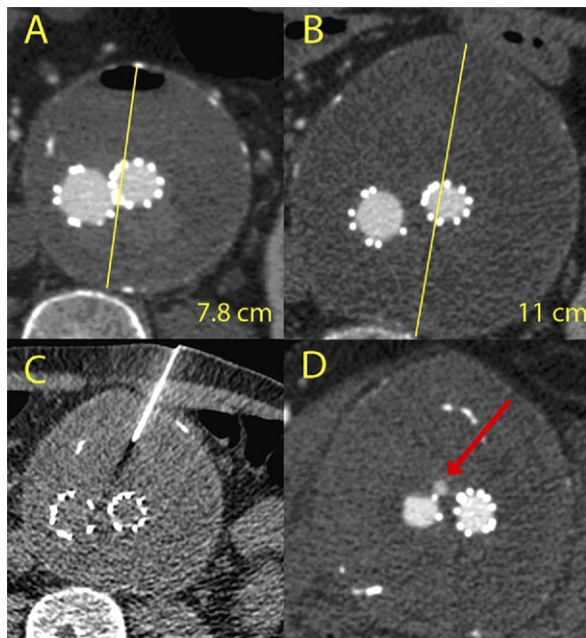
A, Computed tomography (CT) imaging on the second postoperative day shows aneurysm reduction from 8.4 to 7.8 cm, with no evident endoleak. B, At 2 years, the aneurysm had grown to 11 cm, but there was no evident endoleak. C, CT imaging of the second thrombin injection shows the needle clearly positioned outside the stent graft. D, CT imaging 2 weeks after the second thrombin injection shows aneurysm rupture and extravasation of contrast (*arrow*) due to a type III endoleak.
